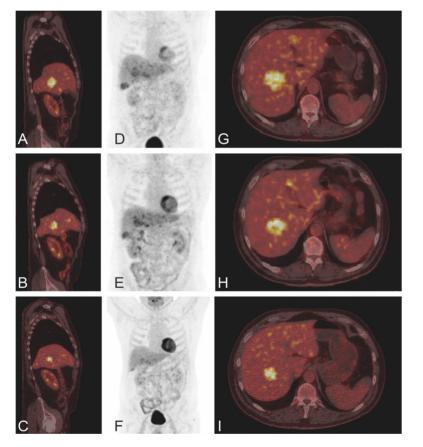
Response monitoring of liver metastases. PET/CT (A, B, C, G, H, I) and maximum intensity images (MIP)(D, E, F) before (A, D, G), after one week of therapy (B, E, H) and after 3 cycles (C, F, I).
